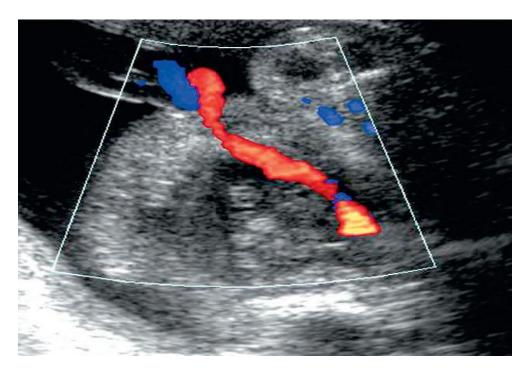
Color Doppler ultrasound adjacent to fetal bladder shows a single Umbilical artery. (Romak ,2011).
